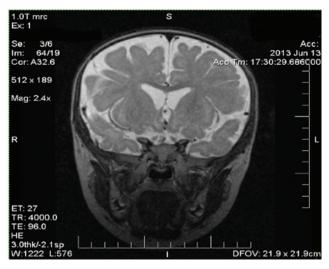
MRI of patient X. Periventricular leukomalacia is the description for mucopolysaccharidosis.
